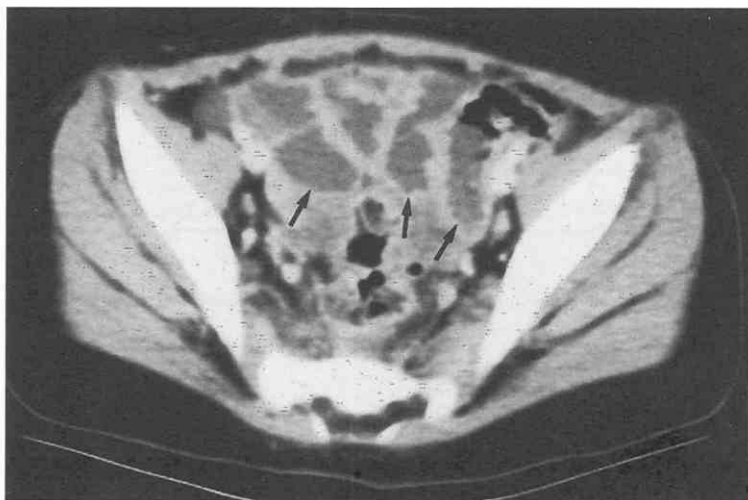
Malignant sacrococcygeal germ cell tumor in a 1-year-old girl. Surveillance CT examination was performed to evaluate for metastatic disease. Because the child refused to drink contrast media, a fruit-flavored clear liquid was administered in place of iodinated contrast material. Note the excellent delineation of the small-bowel loop (arrows) in the pelvis. The small bowel and the large bowel were also well visualized in the upper abdomen (not shown) as a result of a combination of intraluminal fluid and gas.
